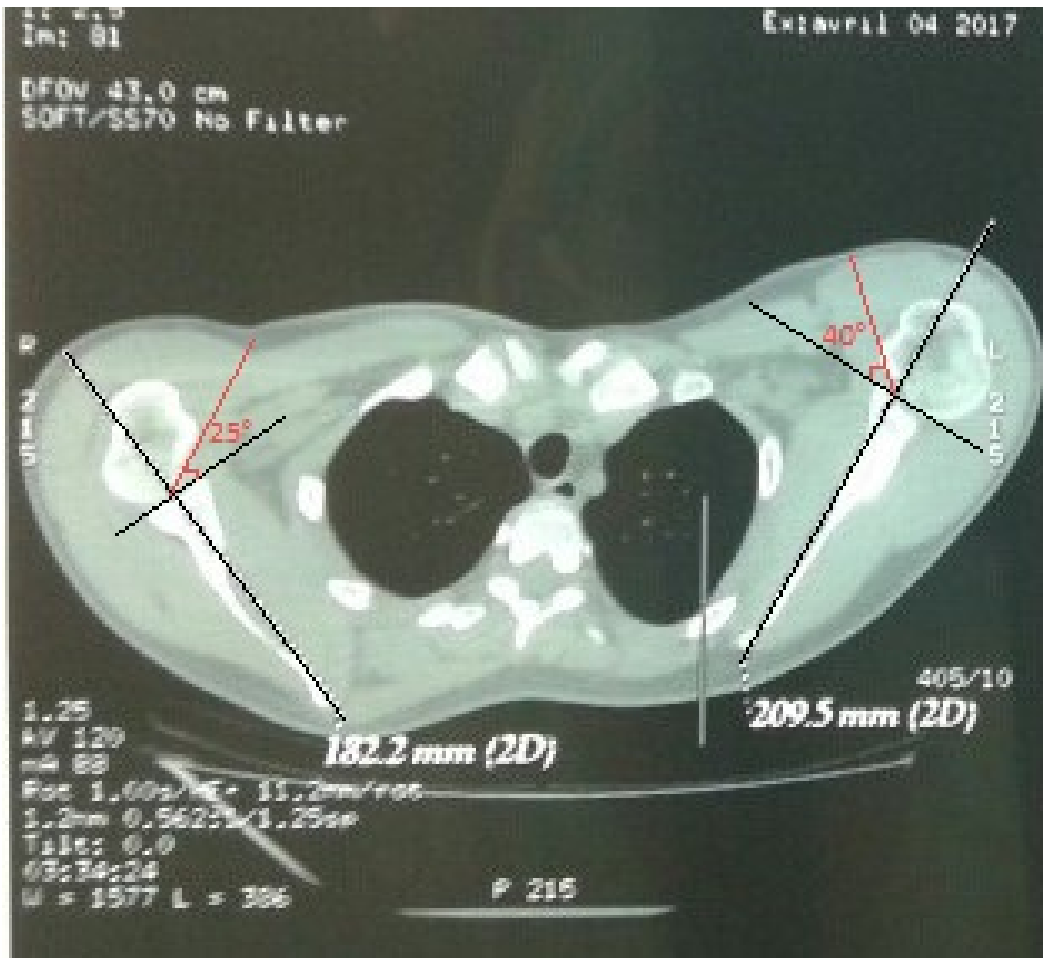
Axial CT showing the degree of version of glenoid cavity on both shoulders.
